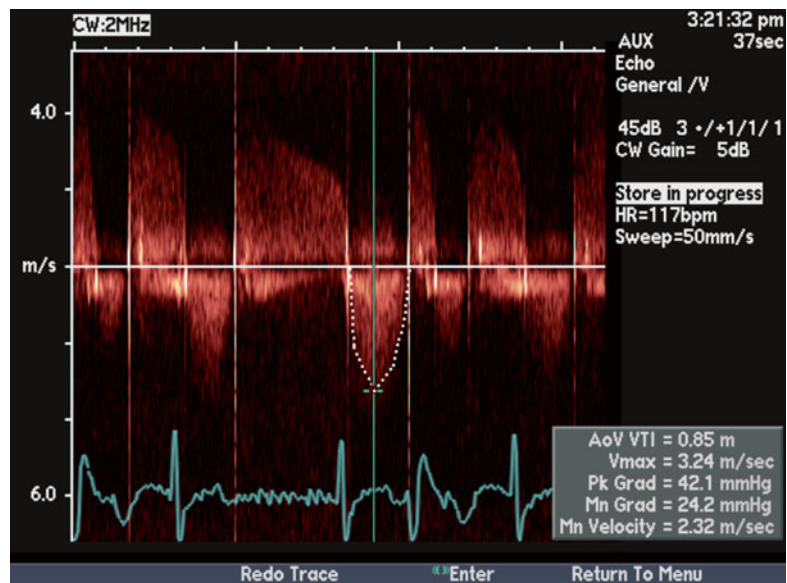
Continuous wave Doppler across prosthetic mechanical aortic valve
